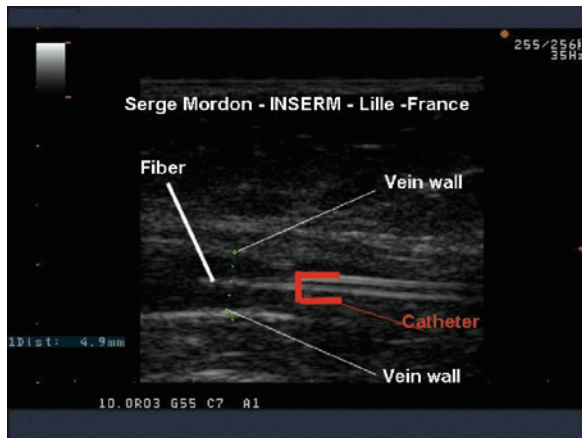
Ultrasound image showing the catheter and the laser fiber inserted in the Saphenous vein
